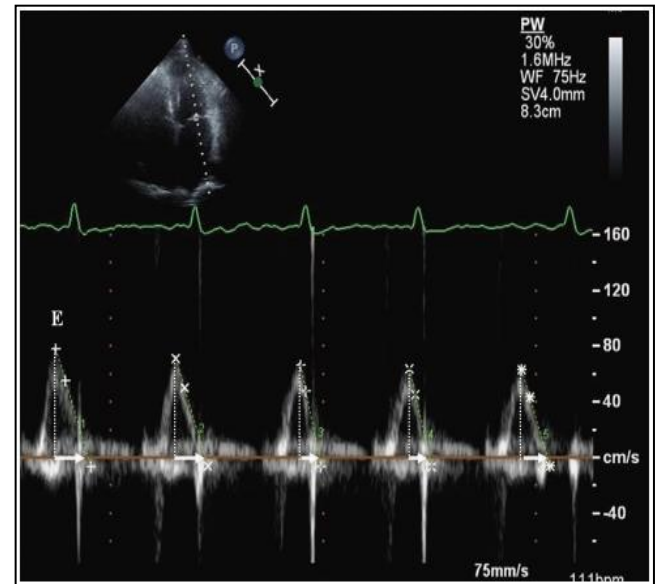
PW Doppler Shows Transmitral Inflow in Atrial Fibrillation. Arrows Indicate Early Mitral Flow Deceleration Time (DT). Peak E Velocity and DT Vary with Cycle Length. (E Represents the Peak Left Ventricular Diastolic Filling Velocity).
